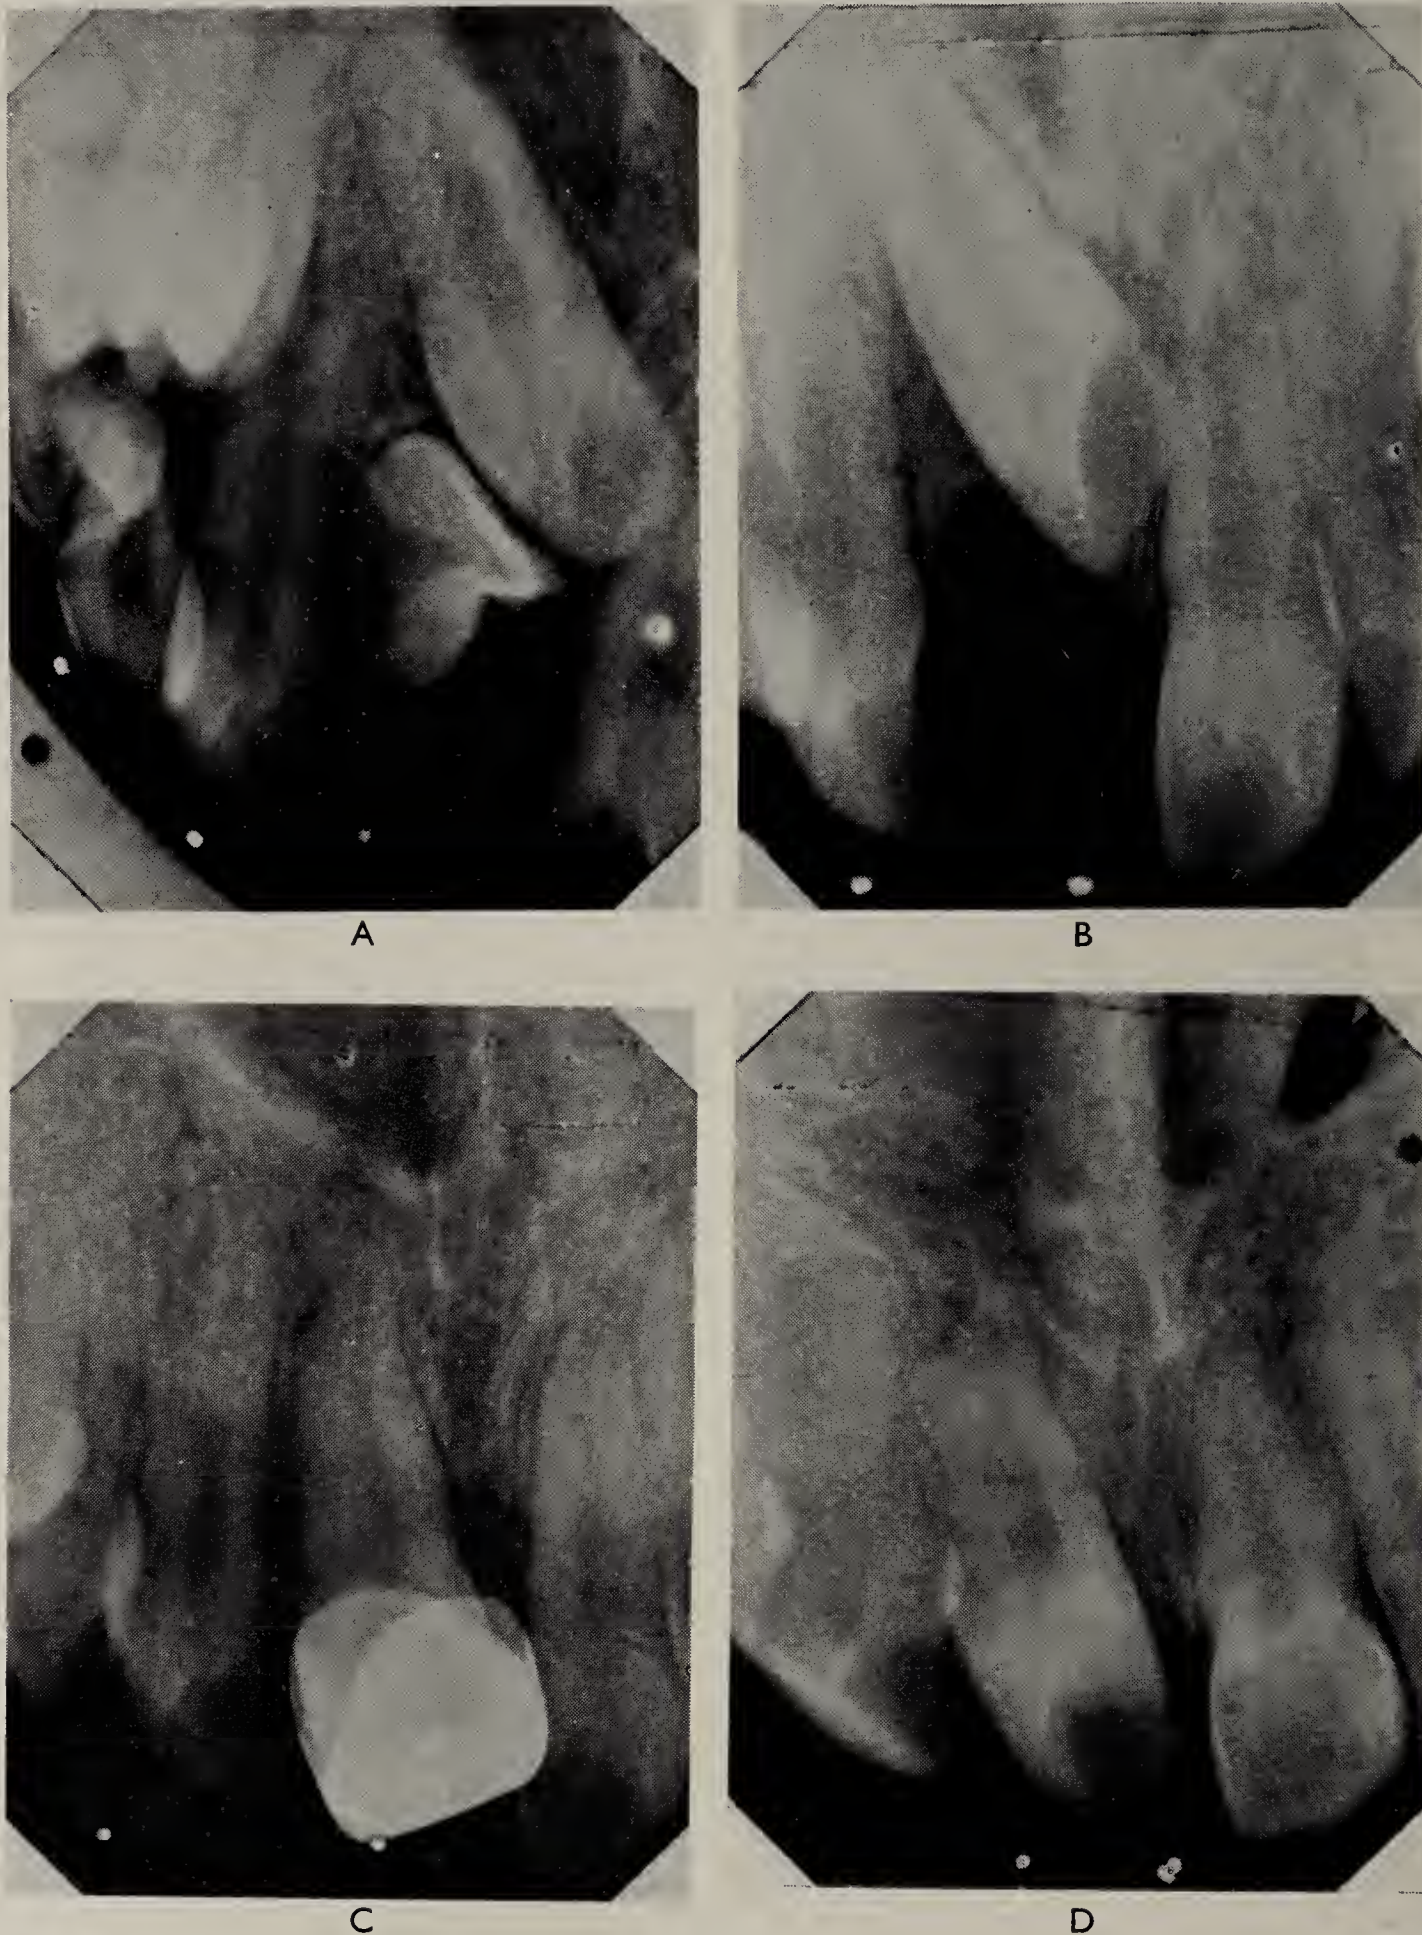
Case 3. Incisiform supernumerary. A, Preoperative X-ray; note apical displacement $\frac{1}{2}$ apex. B, One year post operatively; space adequate within arch for $\frac{1}{2}$. C, Nine months after capping. D, Six months later; slow movement to final occlusal level.
